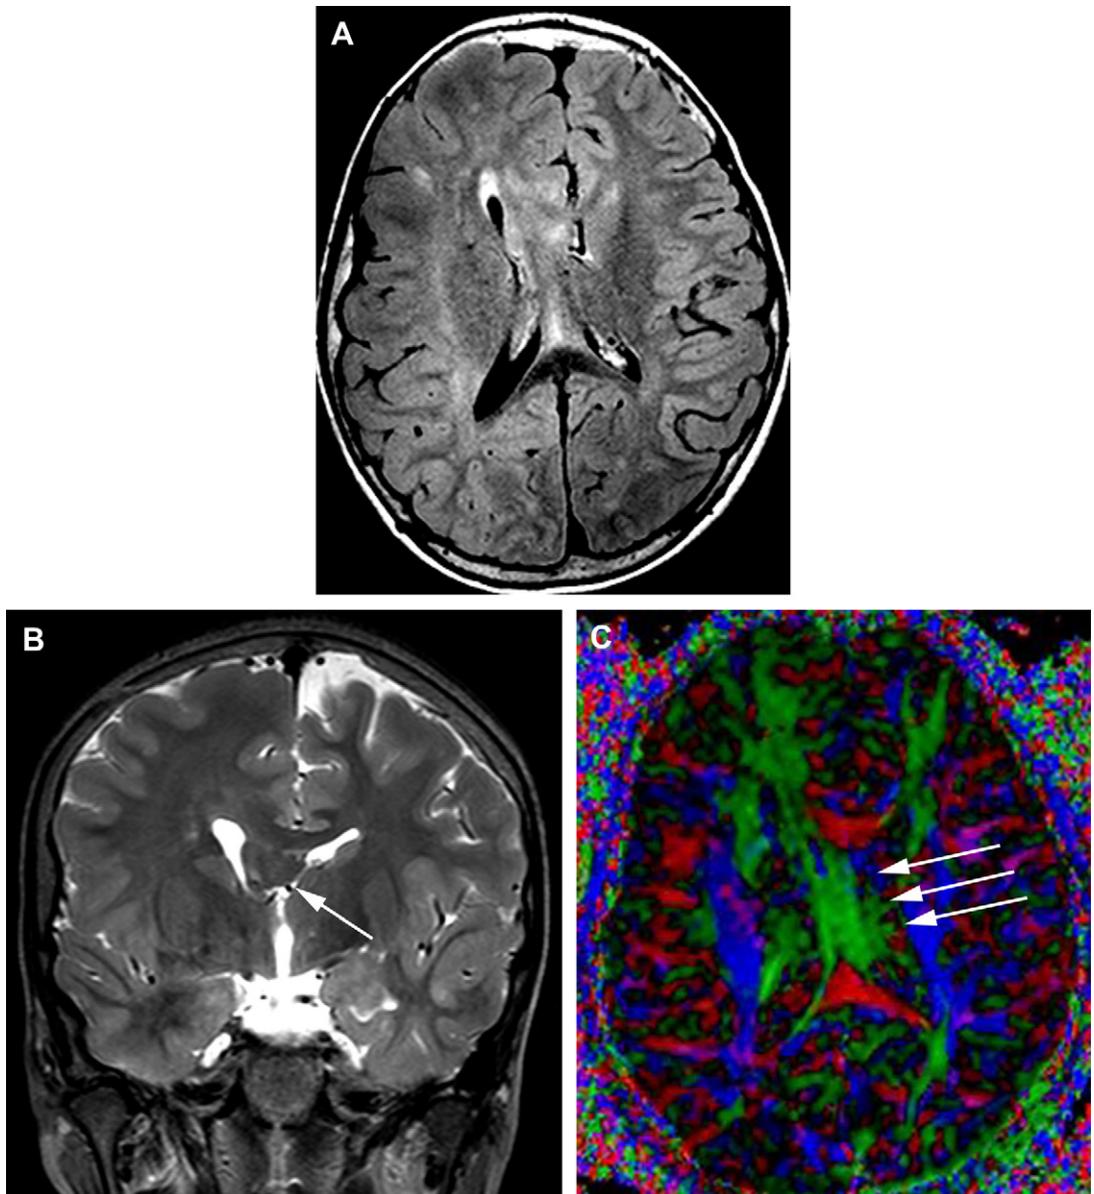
Right anterior HME. (A) Axial FLAIR. Hypertrophy and dysplasia of the right hemisphere, predominantly its anterior portion; the signal of the white matter is heterogeneous; cortex appears thick over the whole lateral convexity, with poor gyration anteriorly; massive dysplasia of the septum pellucidum, which also appears “pulled” toward the abnormal right frontal lobe. (B) Coronal T2 better depicts the heterogeneous appearance of the hypertrophic septum pellucidum (*arrow*). (C) FA color mapping demonstrates that the septum pellucidum conveys a huge abnormal tract of white matter (*arrows*) that extends from the posterior left hemisphere to the anterior right HME.
